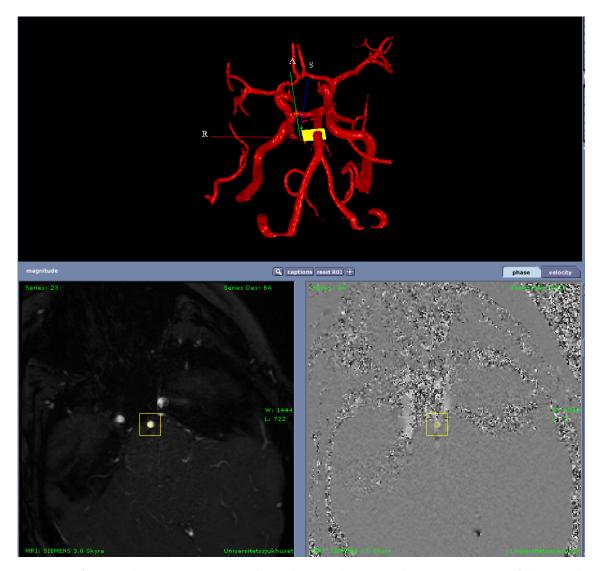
View after 2D phase contrast MRI, where phase and magnitude representations of the vessel are seen.
